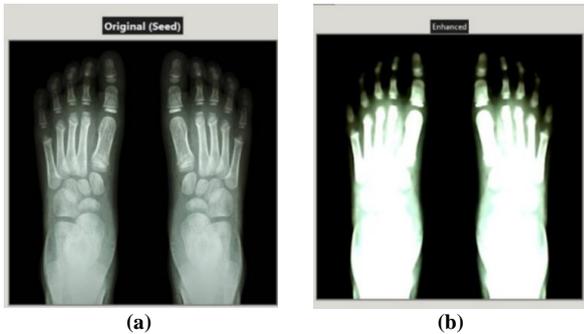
A side-by-side look at the original and enhanced X-ray images. (a) Original X-ray image and (b) Improved X-ray image after using the suggested preprocessing
